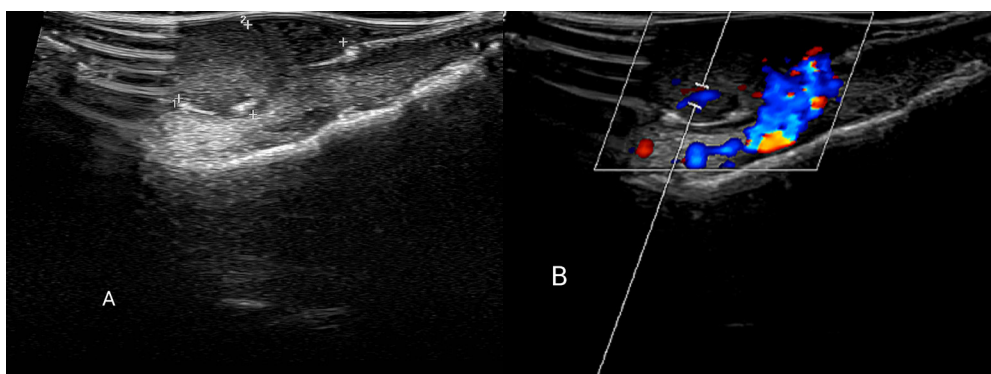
Intraoral Colour Doppler Ultrasonography of the Growth
